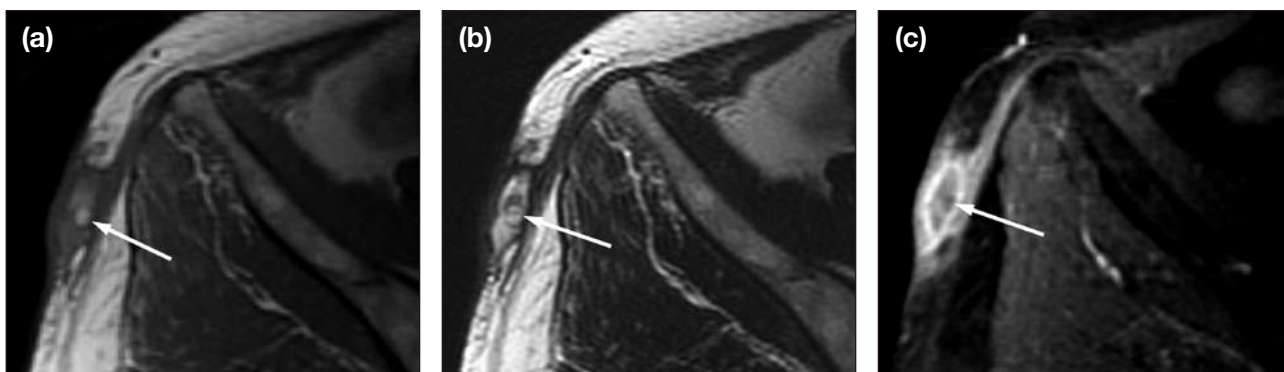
Axial magnetic resonance images showing macroscopic fat (arrow) in the centre of the lesion. There is peripheral contrast enhancement of the lesion, and overlying skin thickening with contrast enhancement. (a) T1-weighted image; (b) T2-weighted image; and (c) Gadolinium-enhanced and fat-saturated T1-weighted image.
